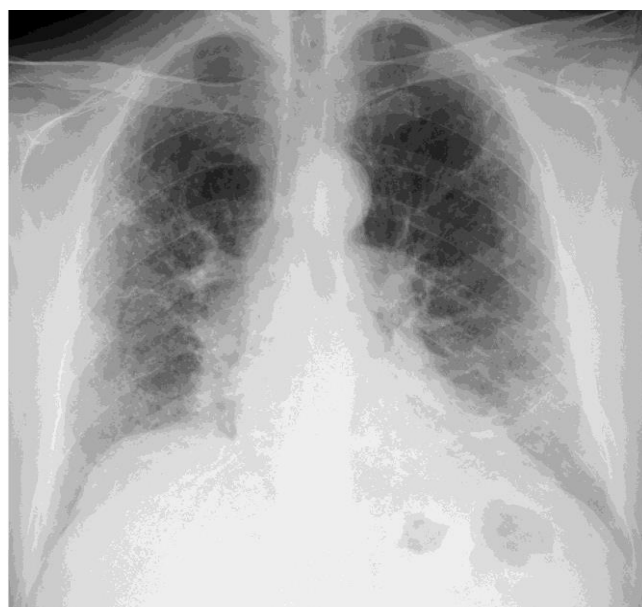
Chest X-ray revealing bilateral reticular opacities and peripheral ground-glass attenuation
